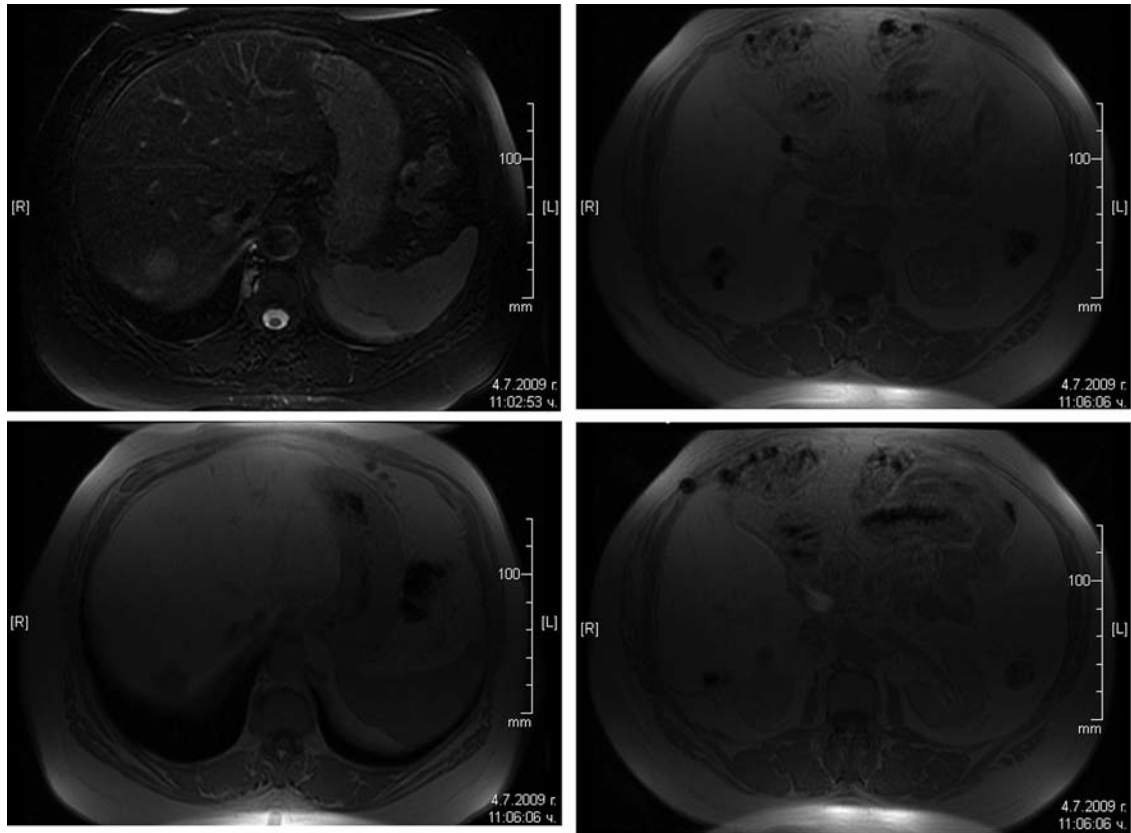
MRI scan of July 2009 revealing new liver lesions after surgery.
